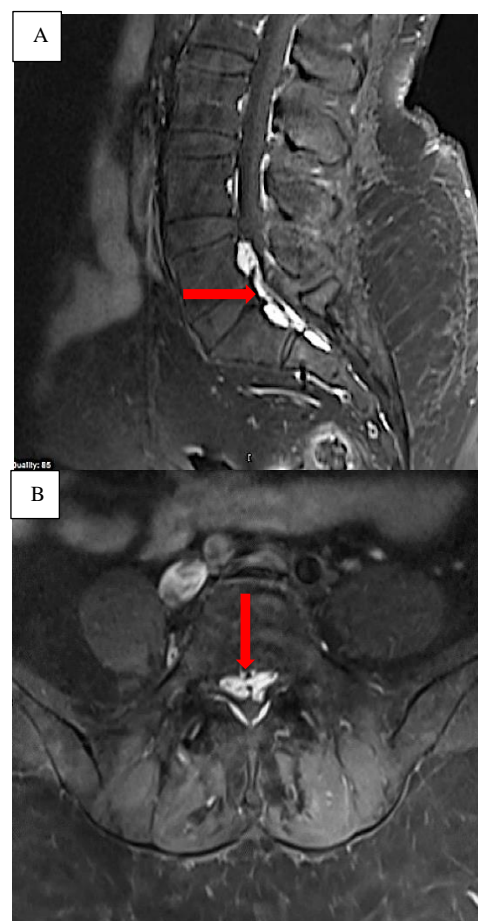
Sagittal (A) and axial (B) T1 fat-saturated sequence magnetic resonance imaging (MRI) with post-contrast enhancement of the epidural veins causing spinal canal stenosis with bilateral compression of the nerve roots
